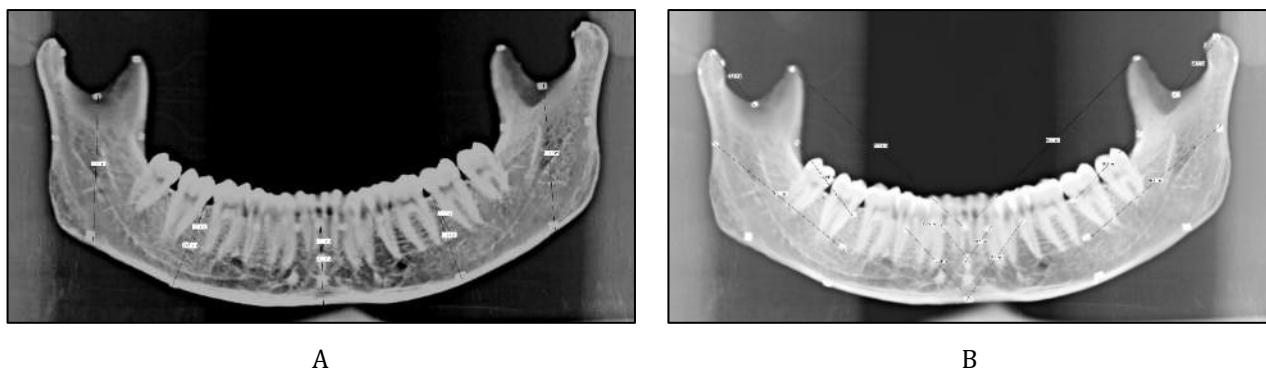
Panoramic radiography of the dry mandible
